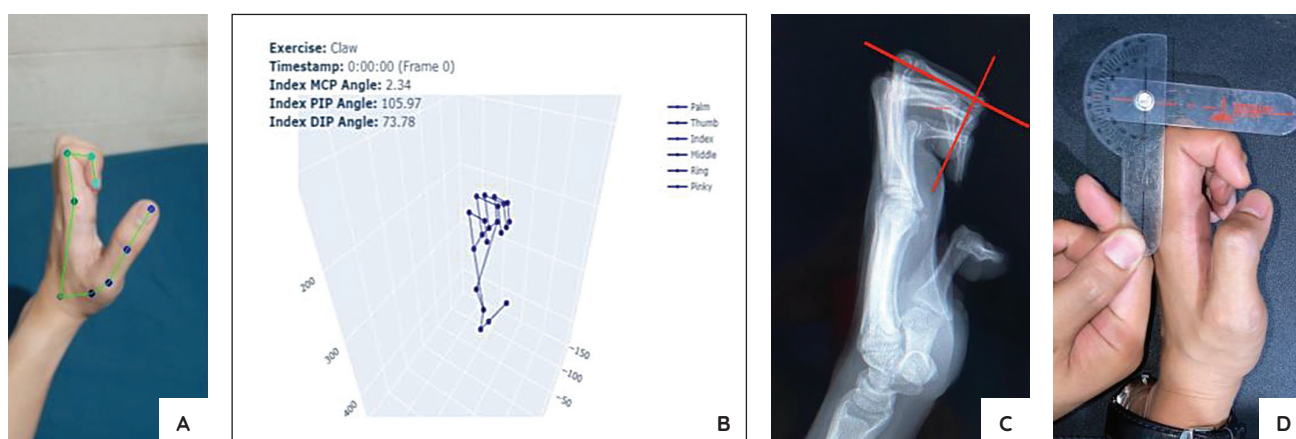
(A) Image of hand with keypoint assignments for Hand Pose estimation model; (B) ROM measurement by Hand Pose estimation model; (C) ROM measurement with radiographic image; (D) ROM measurement with a goniometer.
